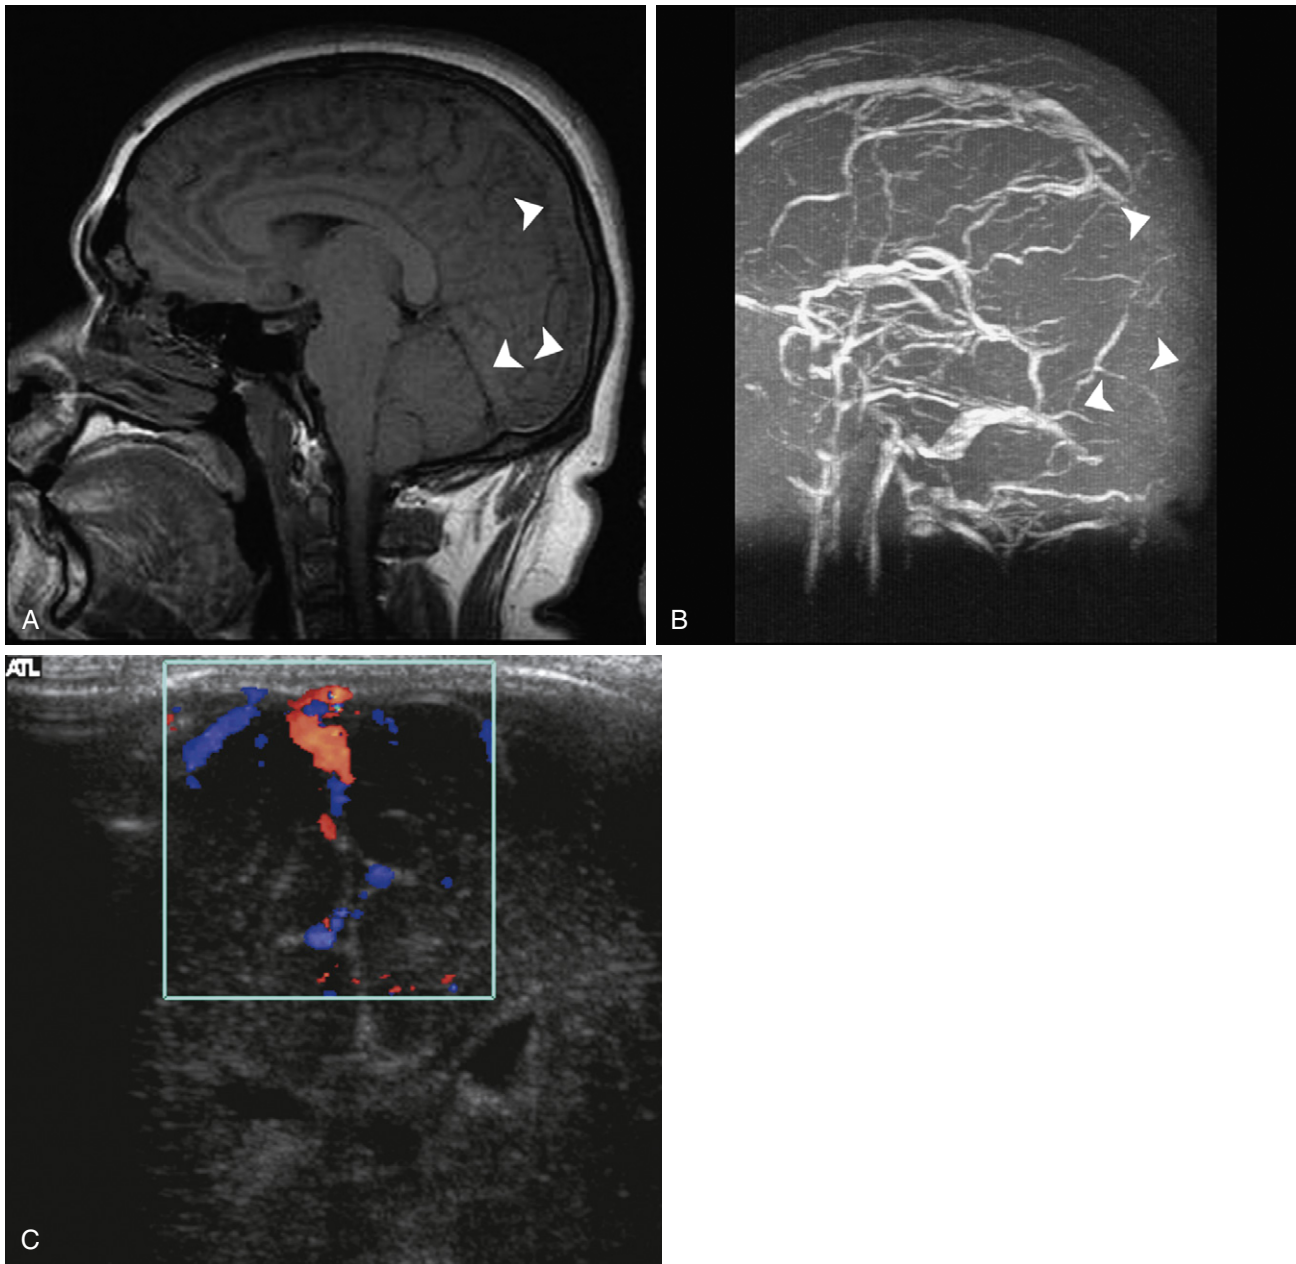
Superior sagittal sinus (SSS) thrombosis on MRV. Sagittal T1 magnetic resonance imaging (A) shows intermediate signal intensity in sagittal and straight sinuses (*arrowheads*). No flow is seen on MRV (B) in these vessels (*arrowheads*), which is consistent with thrombosis. Color Doppler evaluation (C) of the SSS in another 6-month-old patient with suspected thrombosis demonstrated a patent SSS with normal draining cortical veins (see color insert).
